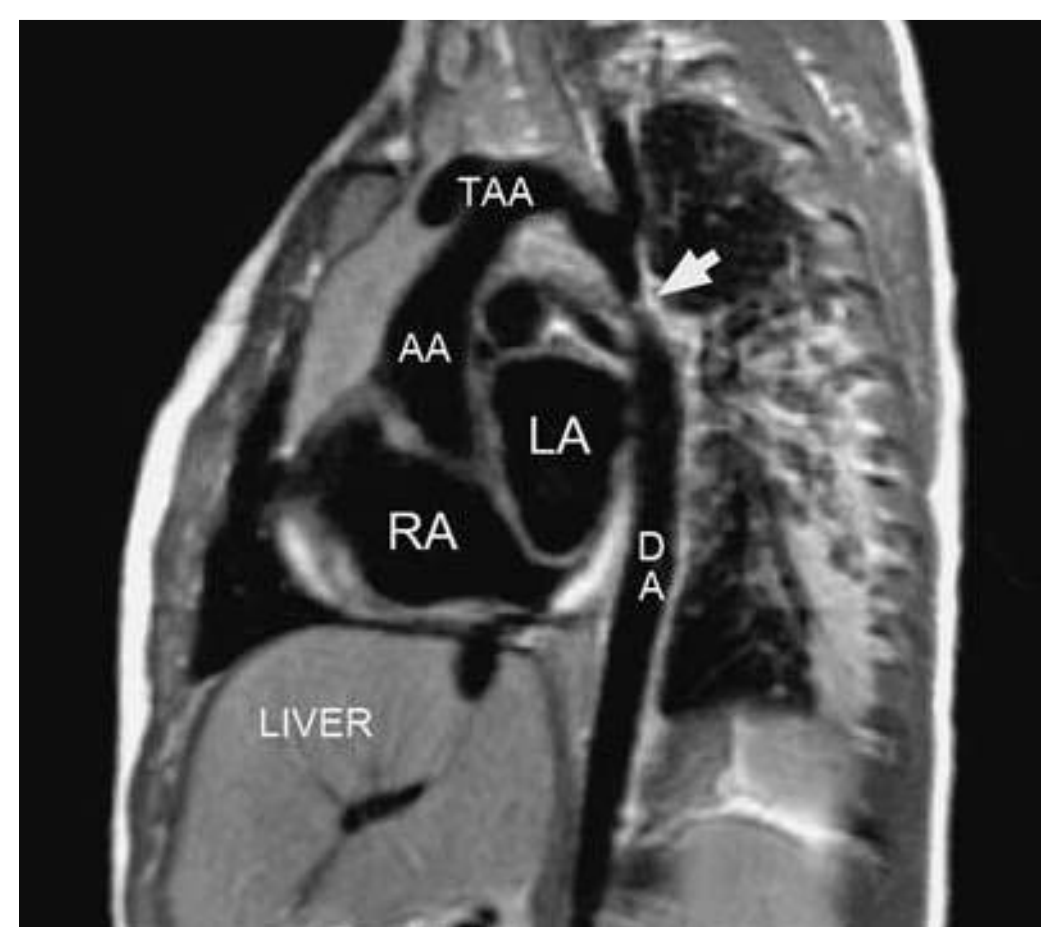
Magnetic resonance imaging of coarctation of the aorta. This lateral view demonstrates coarctation, manifest as a focal aortic narrowing (white arrow). AA, ascending aorta; DA, descending aorta; LA, left atrium; RA, right atrium; TAA, transverse aortic arch.
